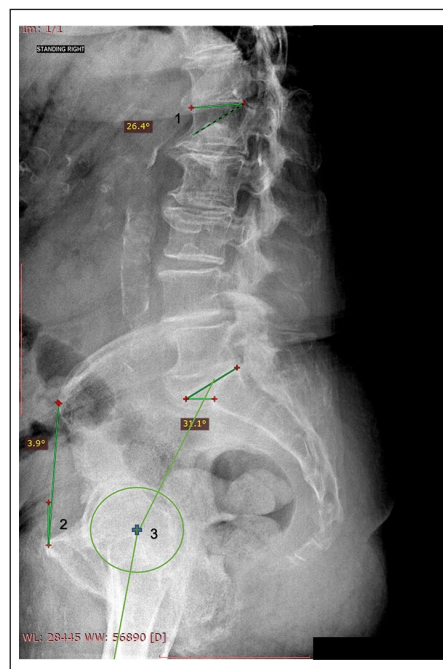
Radiological measurement of spinopelvic parameters. Radiograph in a standing position. The angle 1 represents the lumbar lordosis between the superior endplate of L1 and S1, the angle 2 represents the spinopelvic tilt and the angle 3 represents the pelvic femoral angle.
